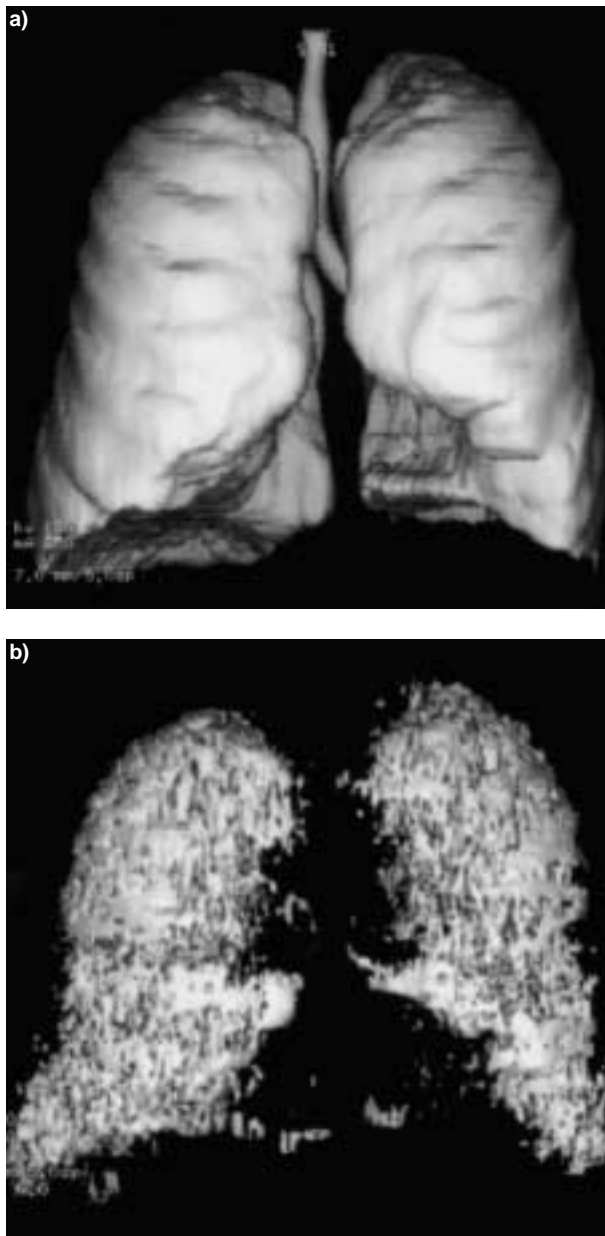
A 55-yr-old patient with a history of cigarette smoking and severe emphysema. Helical computed tomography before lung volume reduction surgery. HCT acquisition with 7-mm sections, reconstruction index of 3.5-mm. a) Three-dimensional surface shaded (3D SSD) model of the lungs using threshold values of (-1024, -400 Hounsfield units (HU)). b) 3D SSD model of the emphysematous lung using threshold values of (-1024, -950 HU shows heterogeneous distribution of emphysema.
